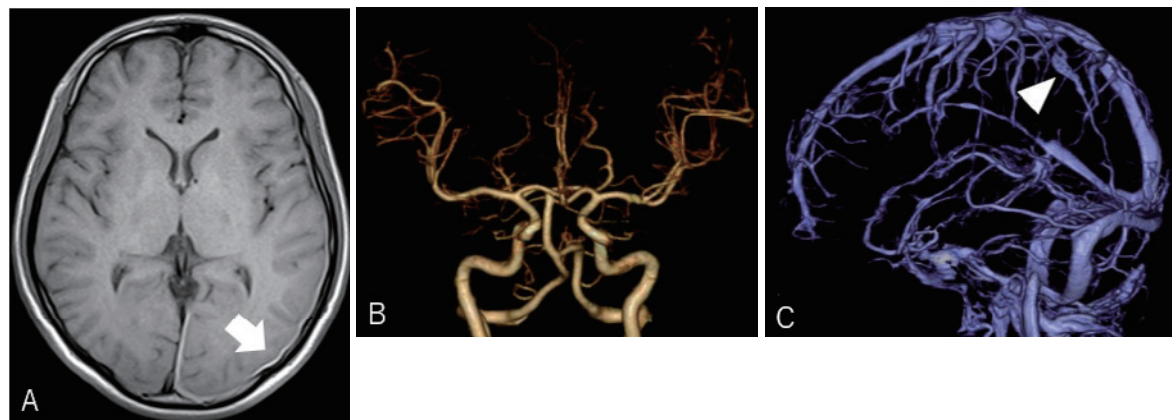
Subdural hematoma (arrow) extending from the parieto-occipital region to the interhemispheric fissure detected on T1-weighted magnetic resonance imaging (A). Contrast-enhanced computed tomography (CT) reveals a prominent diploic vein (arrowhead) on CT venography without obvious vascular abnormalities (B, C).
